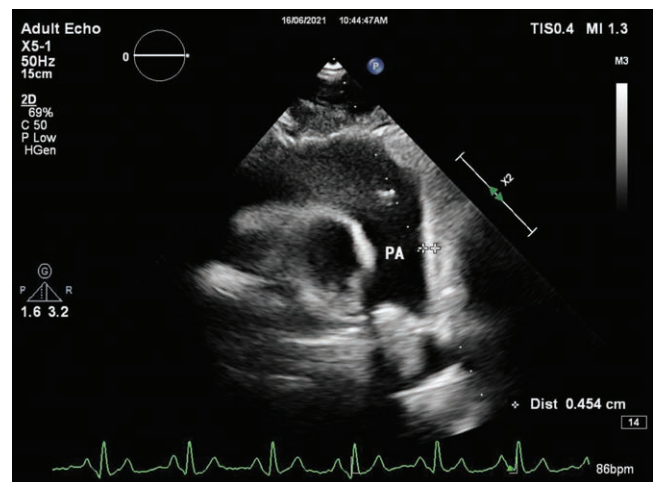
Measurement of pulmonary artery wall thickness by Transthoracic Echocardiography
